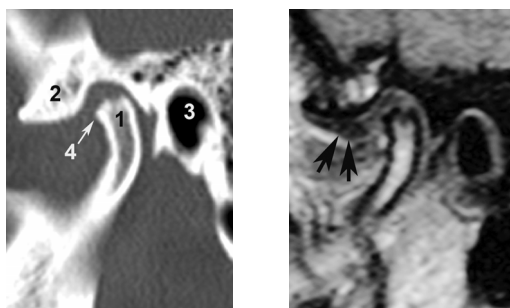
Computed tomography (left) of temporomandibular joint with degenerative bone changes (1 condyle, 2 articular eminence, 3 external acoustical meatus, 4 osteophyte) and magnetic resonance imaging (right) with anterior displaced disc (arrow).
